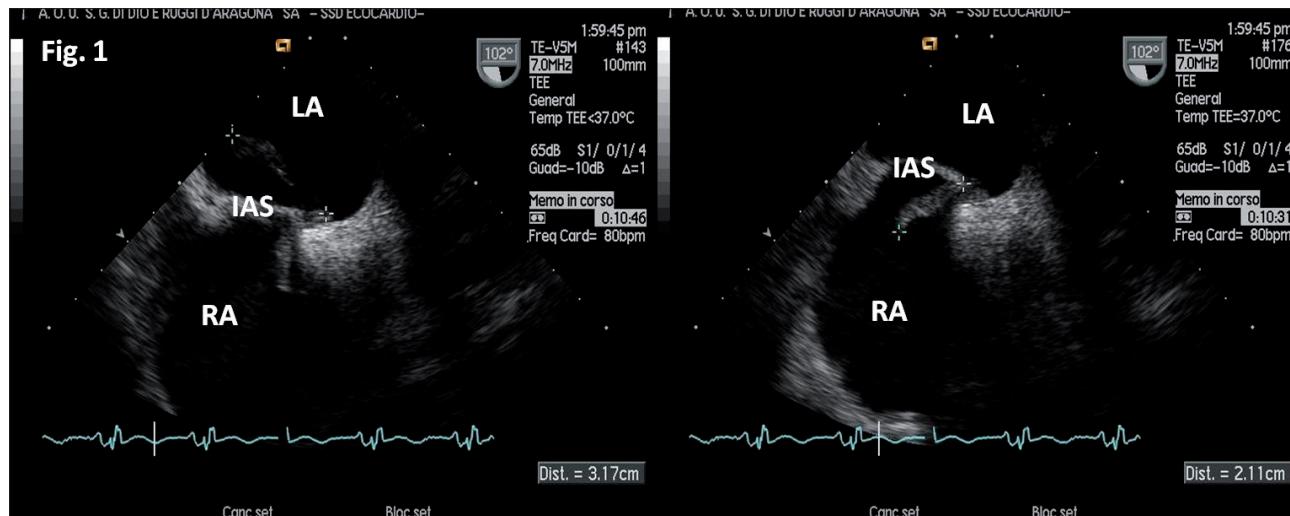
Transesophageal echocardiography shows a large mobile thrombus straddling the patent foramen ovale and extending from the right to the left atrium, with a club-like morphology. Most of the thrombus was in the left atrium (31.7 x 8 mm), and the remaining in the right atrium (21.1 x 8 mm). LA, left atrium; RA, right atrium; IAS, interatrial septum; Ao, aorta.
